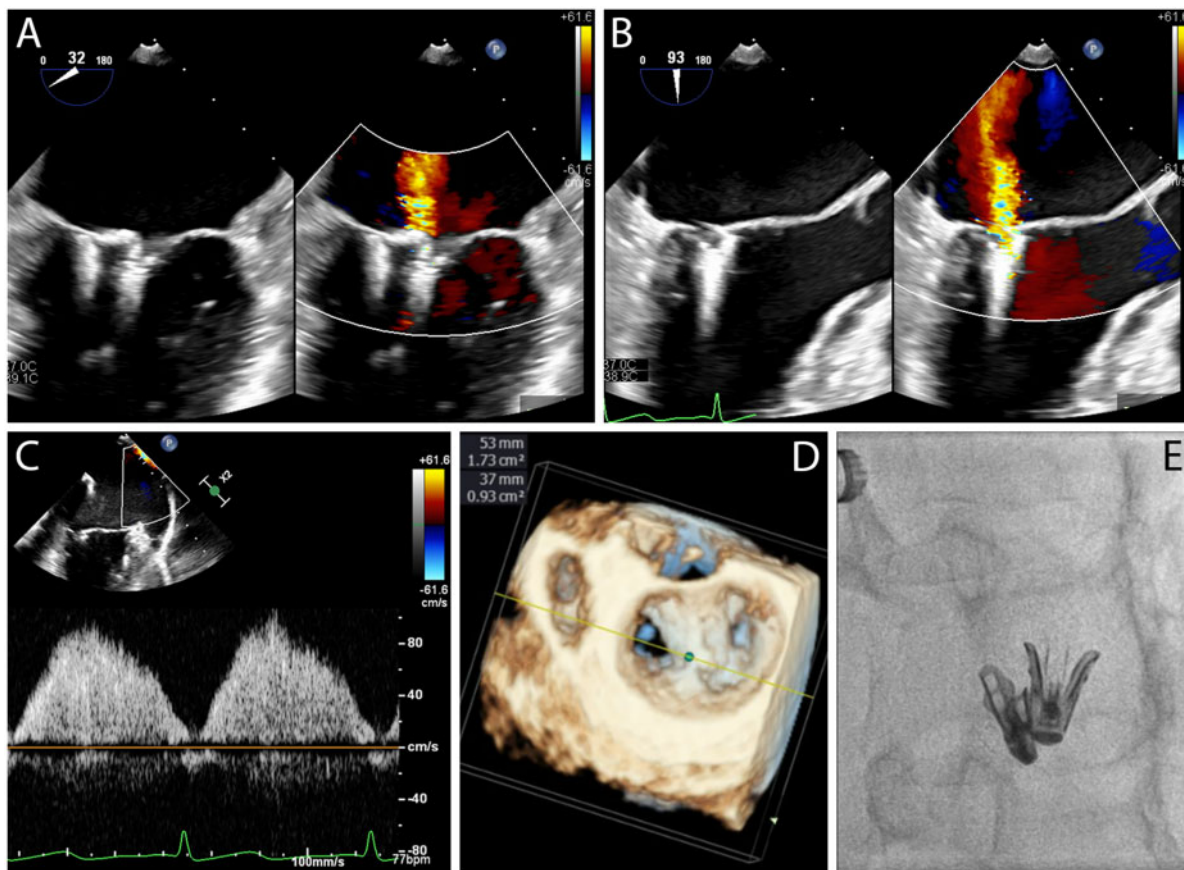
Transoesophageal echocardiogram images showing (A) first MitraClip (NTW) implanted medially at A3/P3 and second MitraClip (NTW) implanted centrally at A2P2 with (B) reduction of mitral regurgitation to 1–2+. (C) Pulmonary venous flow showing systolic predominance. (D) Mitral valve area was 2.66 cm² from the summation of both orifices with a trans-mitral mean gradient of 3 mmHg. (E) Fluoroscopic images showing two NTW MitraClips with wider distance between the clip arms and grippers due to more tissue grasped between them.
